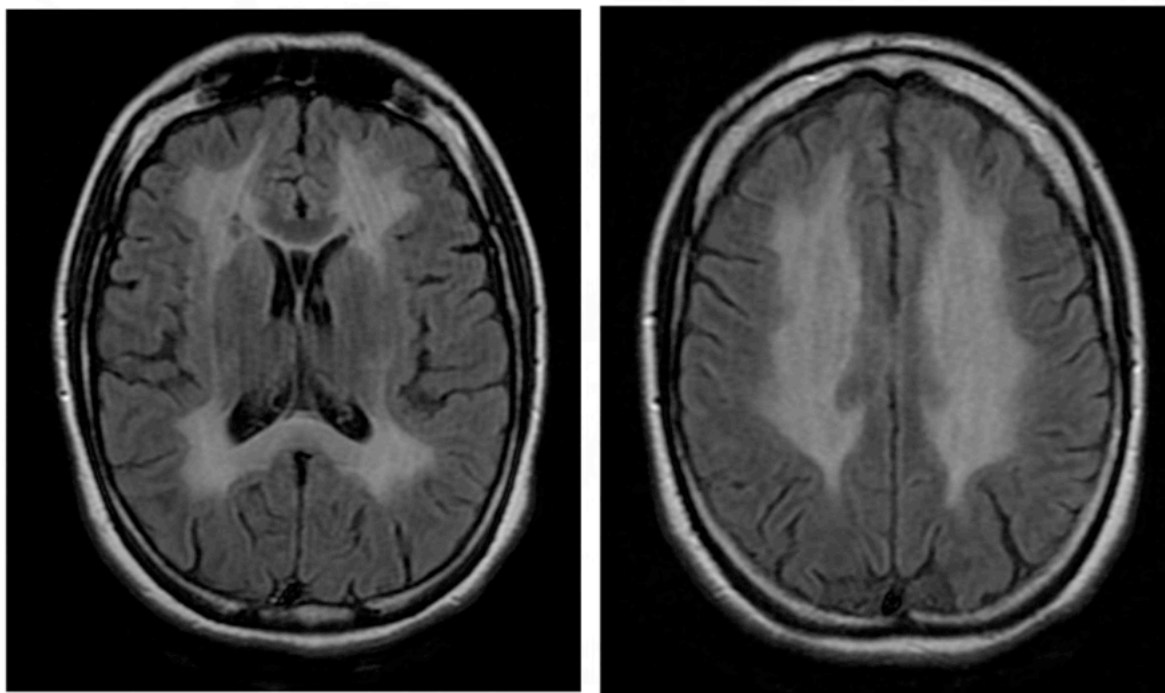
Axial FLAIR images demonstrating extensive bilateral, symmetrical hypersignal on supratentorial bilateral, symmetrical hypersignal of the supratentorial white matter.
